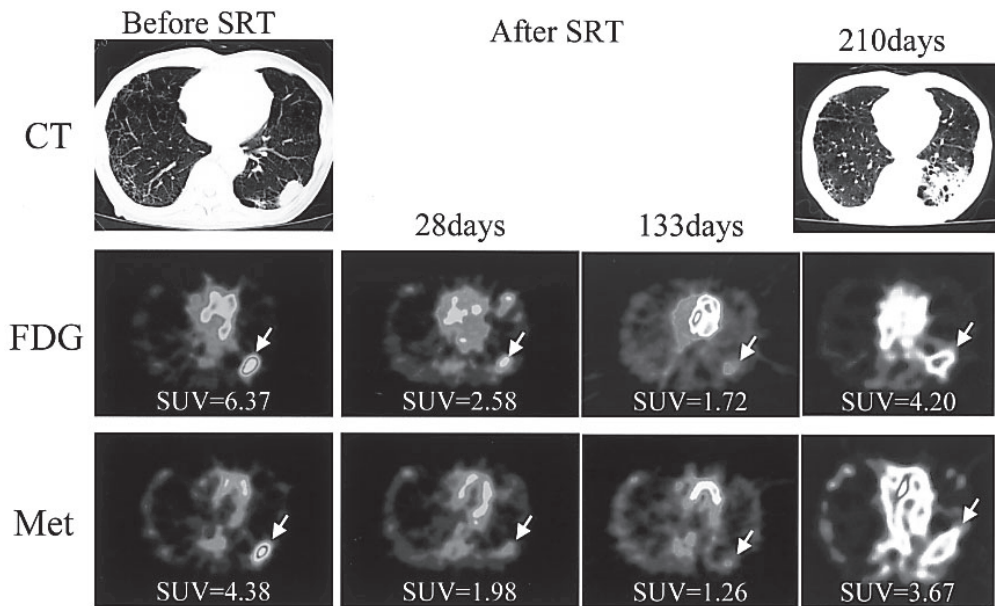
(patient #7). (Left) Before treatment, CT shows a mass (3 cm) in the left lower lung (S9). FDG- and Met-PET show high tracer uptake in the tumor. (Middle) Both at 28 and 133 days after SRT, the uptakes of FDG and Met in the tumor have decreased steadily. (Right) Seven months after SRT, CT shows consolidation surrounding the tumor area, consistent with radiation-induced pneumonitis. FDG- and Met-PET show higher uptake in the corresponding area. The uptake of the tumor cannot be separated from that of inflammation.
